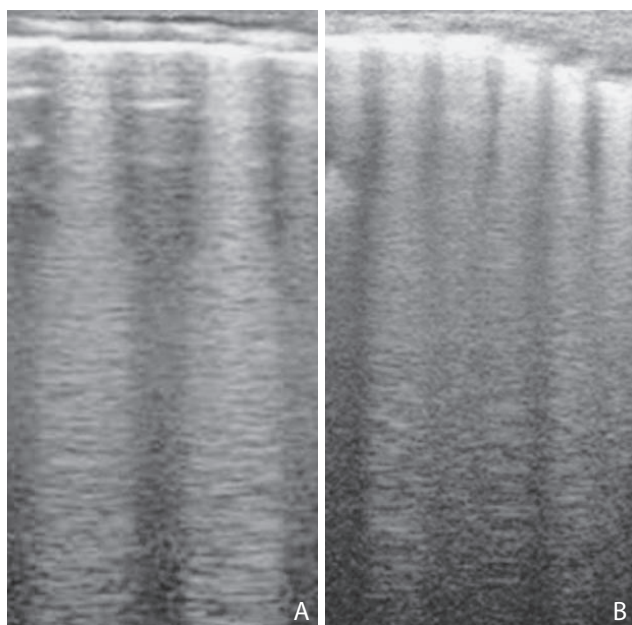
Interstitial edema: B lines combined with "spared areas" of normal lung ultrasonographic pattern (A), and alveolar-interstitial edema as a compact pattern of B lines (B).
